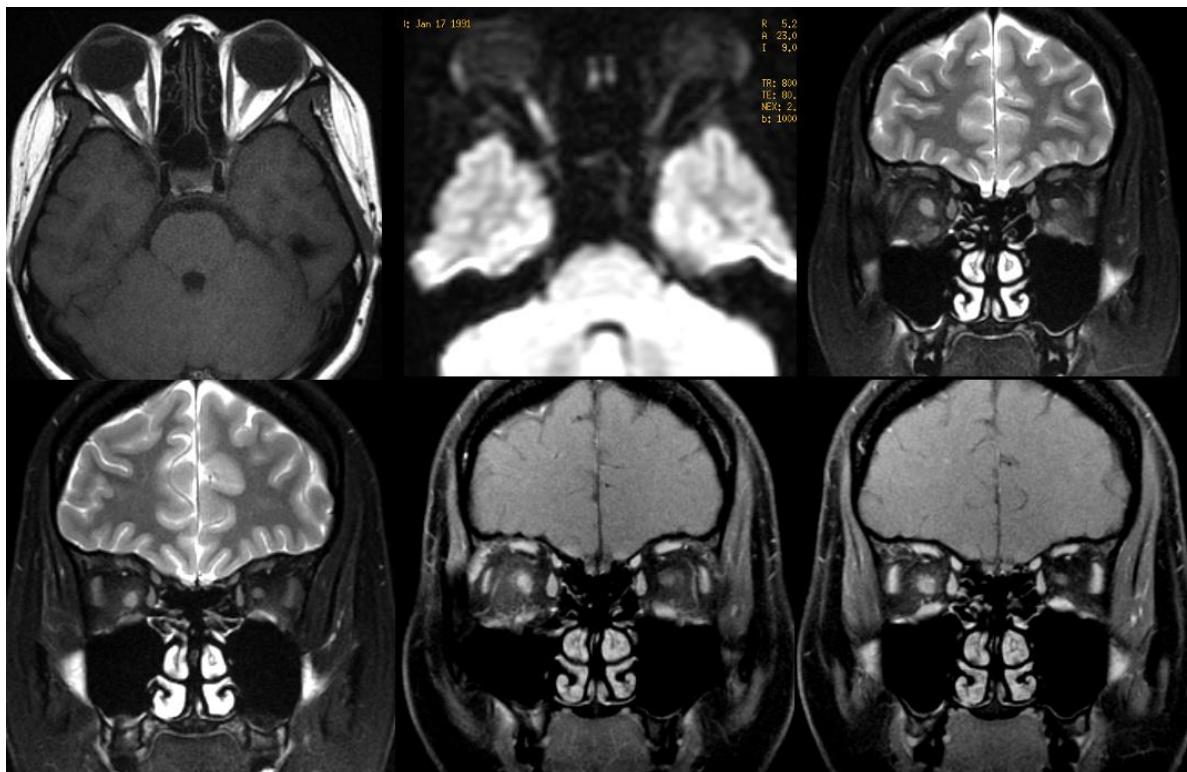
Wanita, 47 tahun dengan gangguan penglihatan kedua mata, MRI T2FRFSE menunjukkan multiple lesi iso hingga *slight hypointense* T2 di extraconal, intraconal post septal orbita kanan kiri, DWI menunjukkan restricted diffusion dan dengan pemberian kontras tampak *slight heterogenous* dan *rim contrast enhancement*. Advanced MRI dengan DCE perfusion menunjukkan TIC type 3, permeability study menunjukkan peningkatan Ktrans, Kep, IAUGC dan Ve. Gambaran sesuai dengan keganasan, multiple nodules metastasis. DCE= Dynamic contrast enhanced, TIC= Time intensity curve, Ktrans and Kep: transfer constant sesuai dengan wash in and wash out, IAUGC= Initial area under gadolinium contrast, Ve: Volume extravascular extracellularare. (Sri Andreani Utomo).
